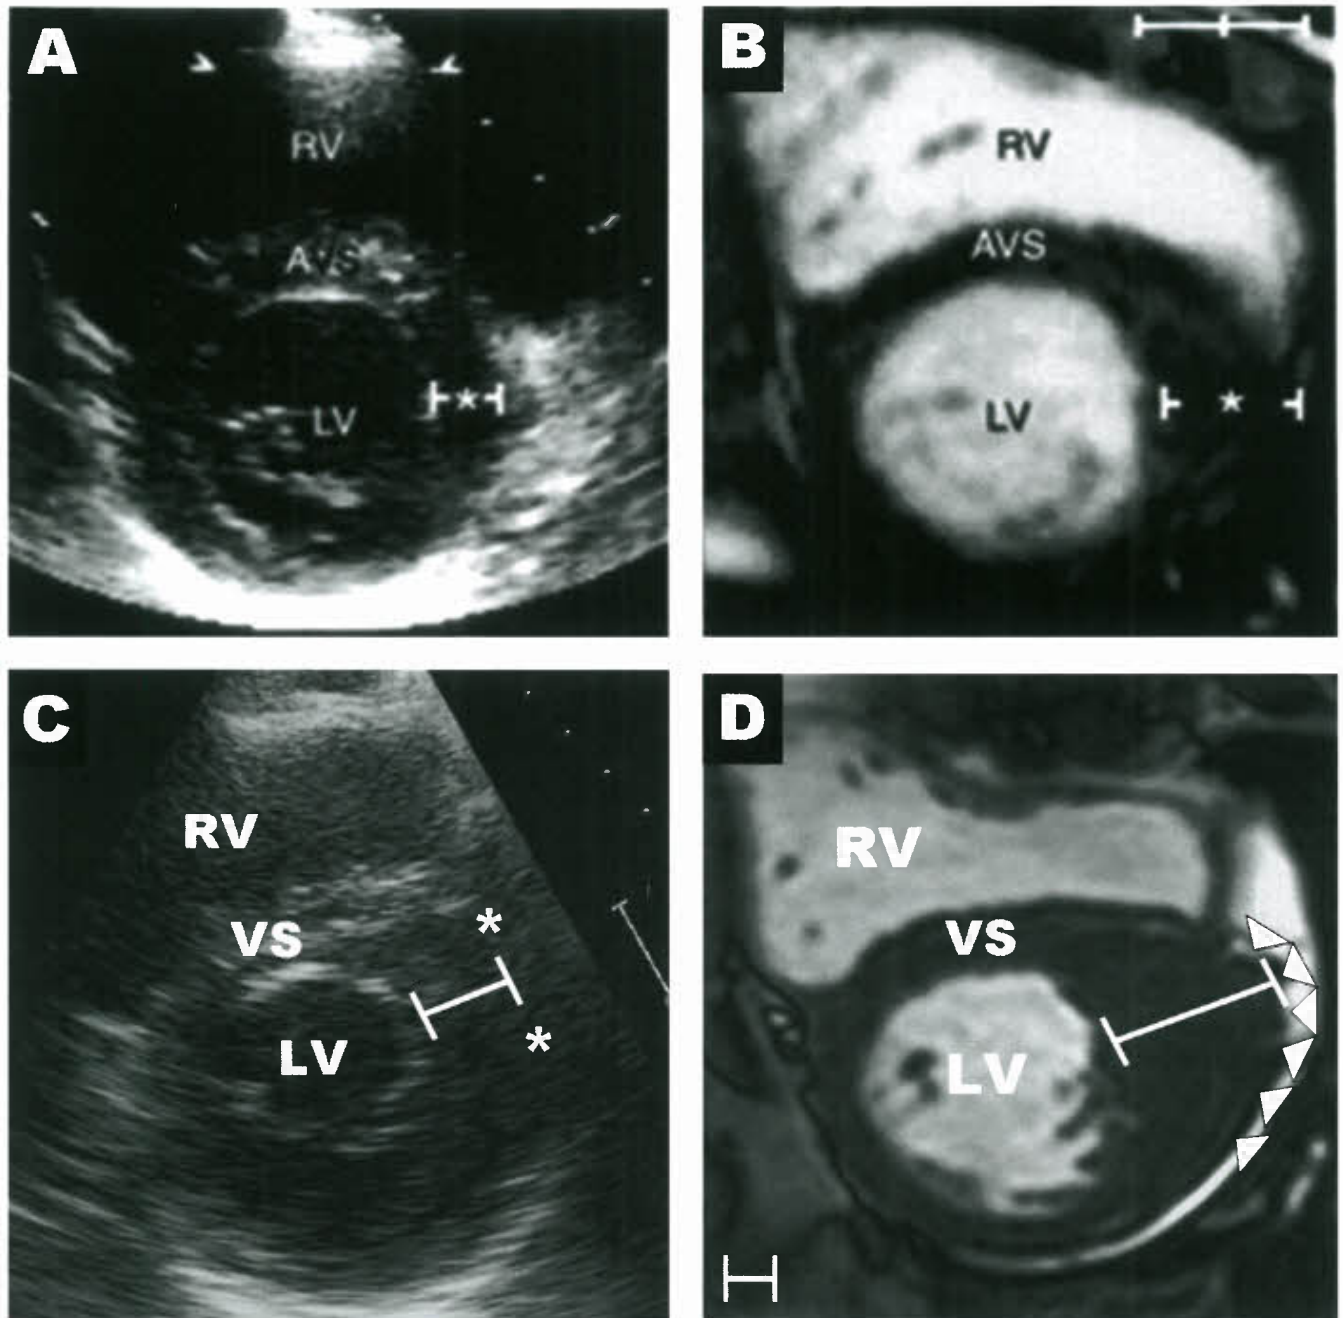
CMR identification of segmental LV wall thickening in HCM. Diagnosis. Two-dimensional echocardiogram (A) and comparative CMR (B) images acquired in short-axis plane at end-diastole at the same level from 13-year-old asymptomatic identical twin. A: Echocardiogram shows normal anterolateral free wall thickness (asterisks). B: CMR shows segmental area of hypertrophy confined to anterolateral LV free wall (20 mm) and small portion of contiguous anterior septum. Calibration marks are 1 cm apart. (Reproduced from Maron MS, Maron BJ, Harrigan C, et al. Hypertrophic cardiomyopathy phenotype revisited after 50 years with cardiovascular magnetic resonance. *J Am Coll Cardiol* 2009;54:220–228, with permission of AHA). Echocardiogram (C) and comparative CMR (D) from 46-year-old man with HCM. C: Echocardiographic short-axis shows anterolateral free wall thickness of 18 mm. D: CMR shows focal area of massive LVH (wall thickness, 35 mm) in the same region of LV, significantly underestimated by 2-D echocardiography. CMR finding defined high-risk status, prompting altered management strategy with an ICD recommendation for primary prevention of SD. Calibration markers are 1 cm apart. RV, right ventricle. (Reproduced from, Maron MS, Maron BJ, Harrigan C, et al. Hypertrophic cardiomyopathy phenotype revisited after 50 years with cardiovascular magnetic resonance. *J Am Coll Cardiol* 2009;54:220–228, with permission of Elsevier).
